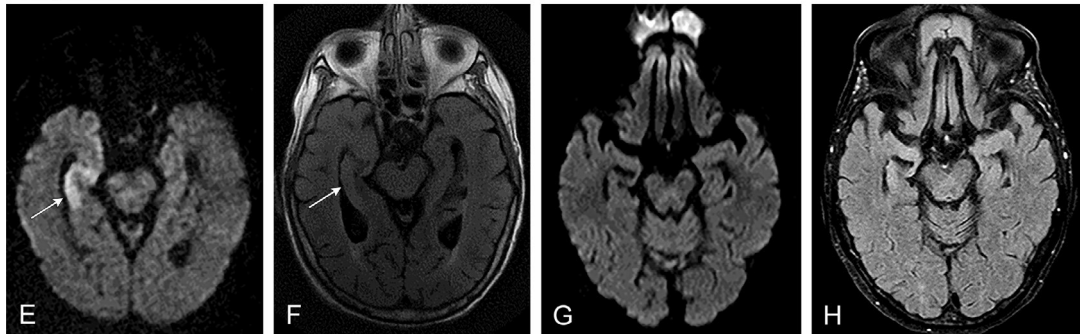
Hippocampal infarction in the setting of vertebral artery dissection. Elderly female presented with acute left sided weakness. Initial DWI (A) showed restricted diffusion in the right mesial temporal lobe (arrow). Initial FLAIR image is normal (B). MRA shows loss of flow-related enhancement in the intradural right vertebral artery (C and D), consistent with dissection. Follow-up imaging in 3 days shows persistent restricted diffusion (E), with increased FLAIR signal (F). There was not associated enhancement or hemorrhage. Two months later, there is resolution of restricted diffusion (G), persistent FLAIR hyperintensity, and (H) volume loss in the region of the hippocampus.
